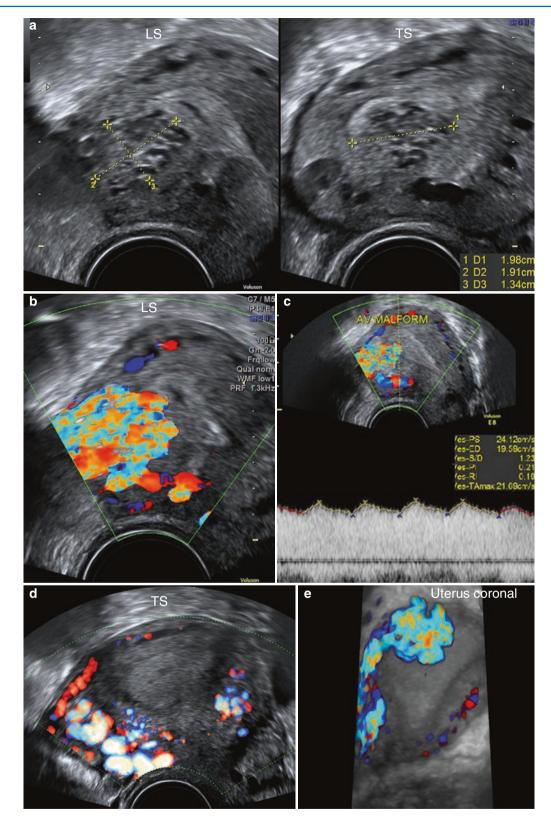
AV malformation of the uterus with normal levels of B hCG (0.1 mIU/mL) and LCB 3 yr and 8 months ago. No history of any pregnancy or surgical intervention following LCB. Last image taken at a repeat follow-up scan done 8 weeks later, showing persistence of the lesion. This is therefore likely to be a true AV malformation. (a) Ill-defined heterogeneous mass comprised of multiple cystic areas is seen in the posterior myometrium of the upper corpus reaching up to the endometrium. (b) The area is seen filling up with colour and shows turbulent flow (high filling with mosaic pattern). (c) High-velocity low-resistance flow is seen. (d) The arcuate and parametrial vessels are seen dilated and tortuous. (e) 3D HD Doppler glass body image showing the lesion with turbulent flow and dilated arcuate and parametrial vessels on the side of the lesion. This image was taken during a repeat scan after 8 weeks of the earlier images
